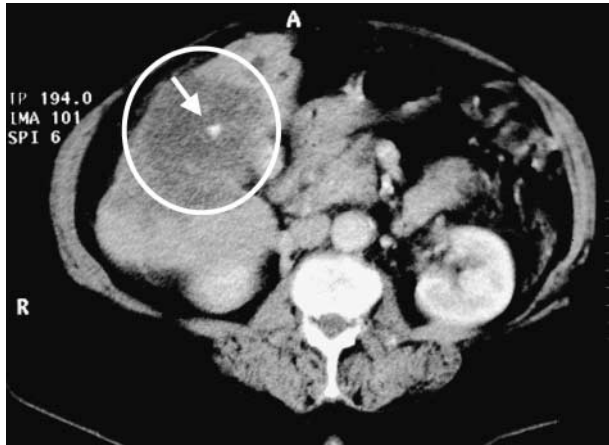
Computed tomography of case's liver showing the parasitic mass (circle), along with a calcified central area (arrow).
